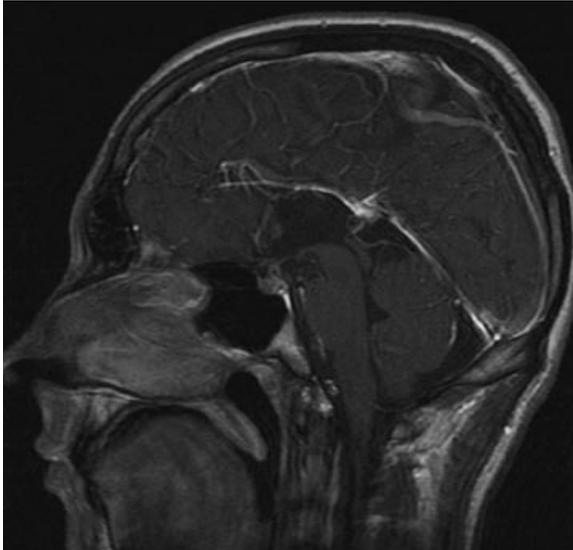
MRI, T1-weighted image, sagittal projection: agenesis of the corpus callosum; commissura anterior visible in front of dilated third ventricle.
